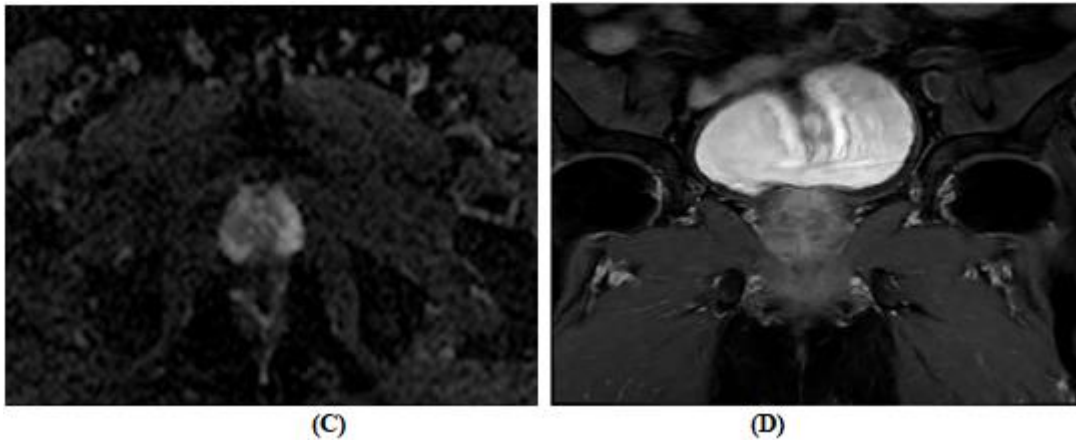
A T2W axial, B DWI at b 2000 axial, C ADC map axial , D Post contrast coronal
